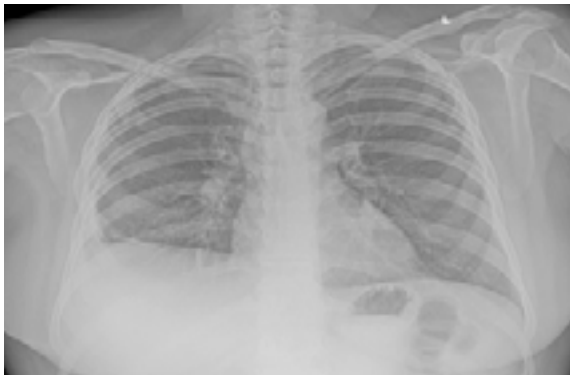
Chest x-ray of the taken on admission revealing Right pleural effusion.
